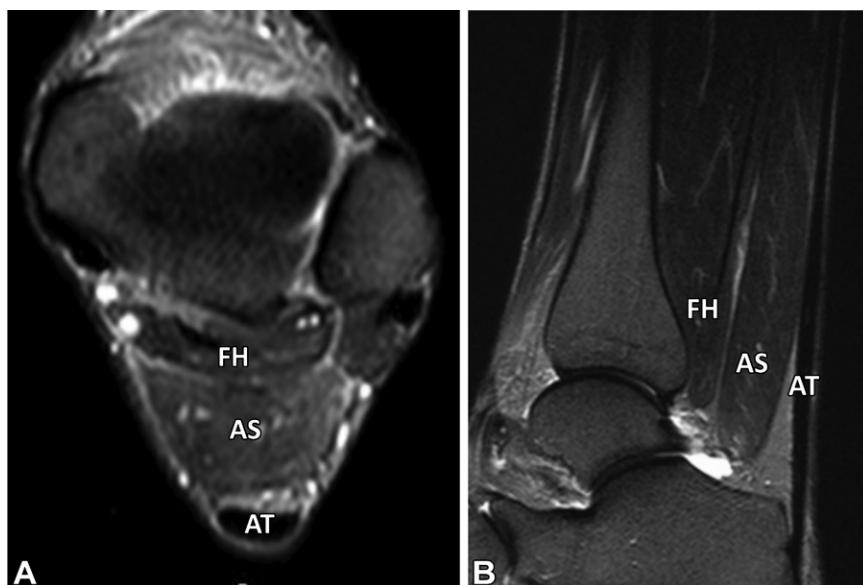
Accessory soleus muscle in a 37-year-old woman with chronic discomfort at the postero-medial aspect of the ankle when exercising. Axial (A) and sagittal (B) STIR MR images show an accessory soleus muscle (AS) between the flexor hallucis longus (FH) and Achilles tendon (AT).
